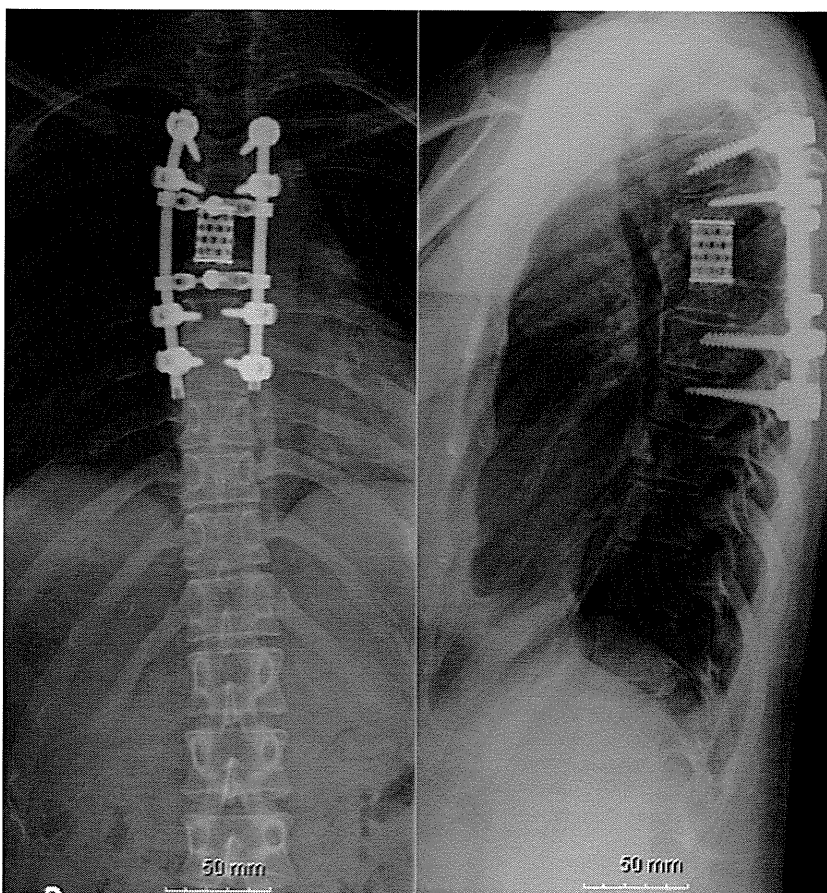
Case 3. Anteroposterior and lateral radiograph of the thoracic spine at the 1-year postoperative follow-up showing restoration of the sagittal alignment after *en bloc* tumor resection and solid bony union.
